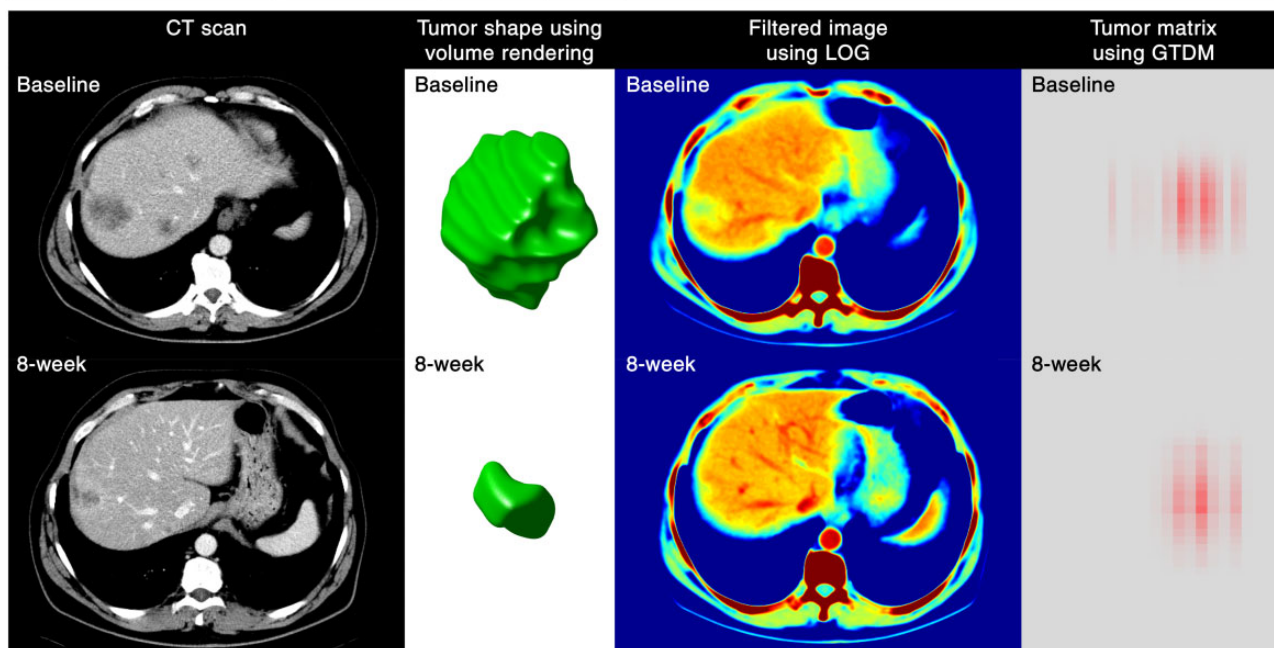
Visual representation of the four imaging features included in the signature. The changes in the radiomics features in the patients with the lowest and the highest probability of insensitivity to treatment according to the radiomics signature are presented on this graph (most sensitive 1–4 vs most insensitive 1–4). The changes in tumor imaging phenotype of the patient “most sensitive 1” is displayed below. As demonstrated, CT-scan images are transformed to other mathematical spaces for feature extraction, for example, CT image is transformed to LOG space for computing the entropy value (spatial heterogeneity), and tumor pixels within segmentation contour are transformed to GTDM matrix for computing the contrast value.
